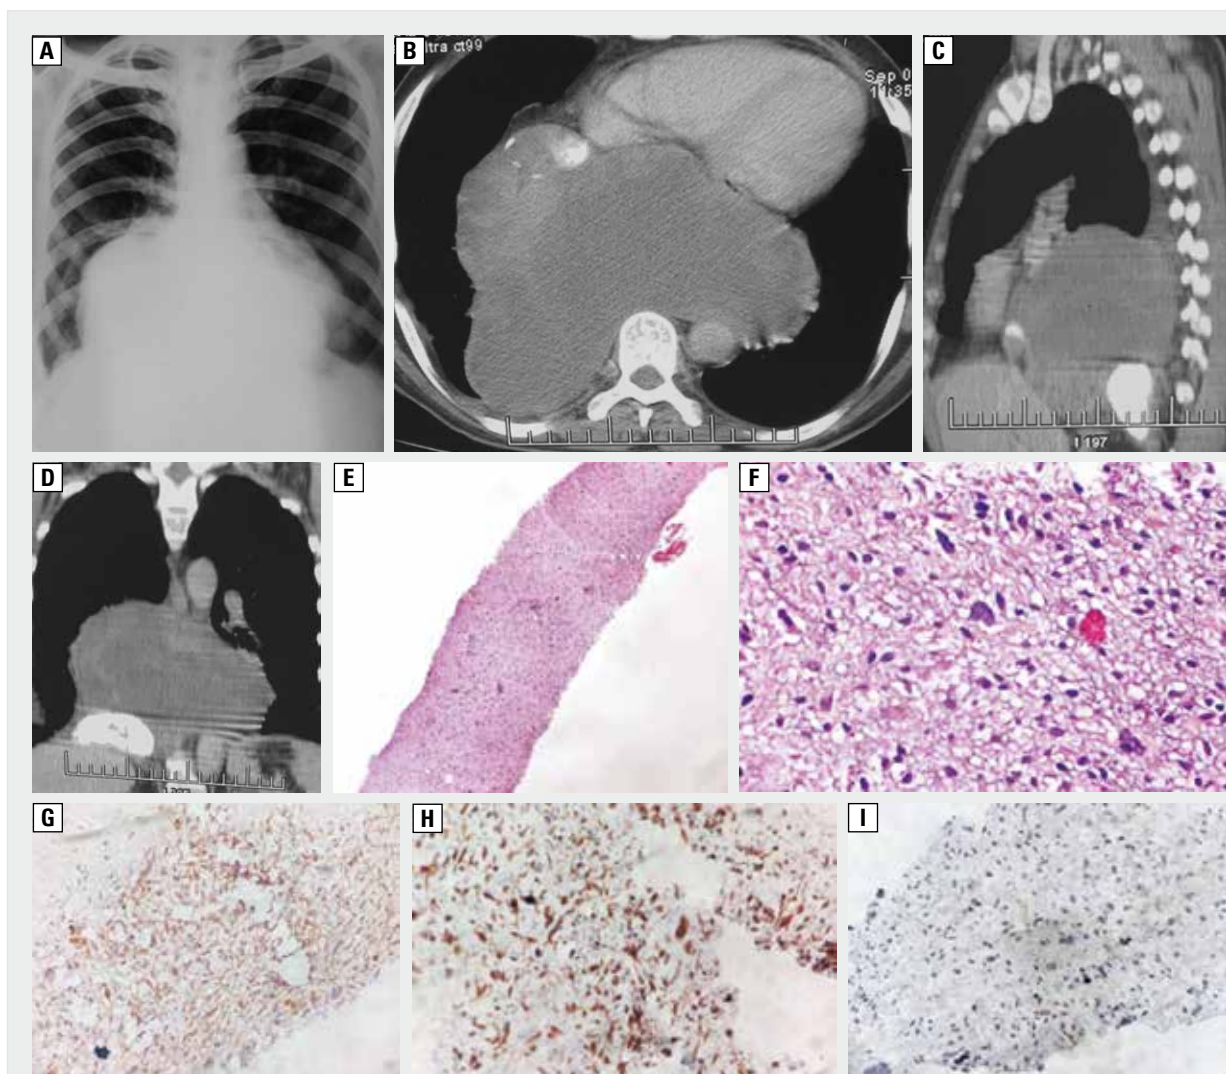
A. Frontal chest radiograph showing a mediastinal mass extending to the both sides of the midline, not silhouetting the cardiac outline. However, diaphragmatic outline is silhouetted, suggestive of likely posterior mediastinal origin; B. Axial CECT image shows heterogeneously enhancing solid posterior mediastinal mass extending to both sides of the midline showing areas of coarse calcification. Descending thoracic aorta is partially encased while the esophagus is not visualised, likely completely encased by the mass. No extension to neural foramen; C and D. Sagittal and coronal reformatted images reveal the vertically oriented fusiform configuration of the mass which is limited to the posterior mediastinum, not extending to the upper retroperitoneum. Note coarse calcification in its caudal aspect and mild right pleural effusion; E. Core biopsy from the soft tissue in low (10 X) magnification mass showing tumour cells; F. Higher magnification (40 X) shows the tumour cells are arranged in diffuse sheets. These cells are pleomorphic, spindle-shaped to elongated, have eosinophilic cytoplasm and hyperchromatic irregular nuclei. Interspersed tumour giant cell can also be seen; G. The tumour cells show vimentin positivity; H. The tumour cells show CD34 positivity; I. The tumour cells are negative for S-100, SMA, Desmin, Calretinin, TTF-1, EMA, Bcl-2
